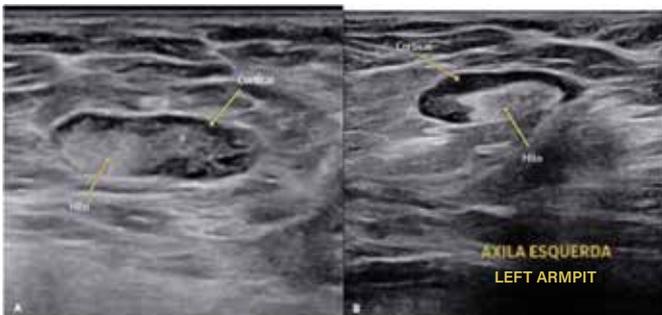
Normal axillary lymph nodes. A. Axillary lymph node showing, on ultrasonography, a thin or barely visible cortical bone. B. Axillary lymph node showing, on ultrasound, regular visible cortical bone measuring up to 2 mm.
